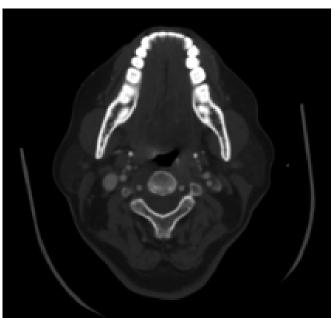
CTA carotid - axial and sagittal views
